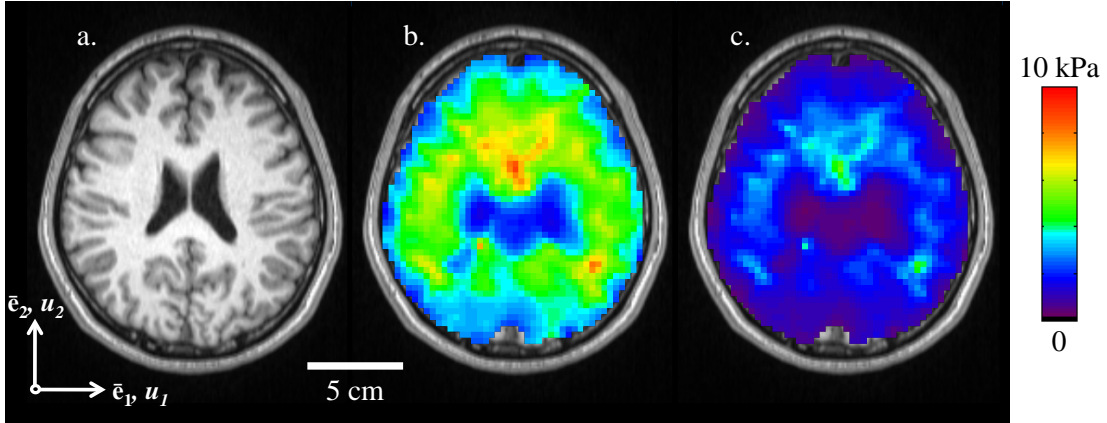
Spatial maps of the viscoelastic material properties of intact, living human brain were calculated using a distortion-based LFE approach (Equation 5.13). (a) T1-weighted anatomical image of the analysis slice. Viscoelastic moduli (b) G' and (c) G'' . (S005, 45Hz)
